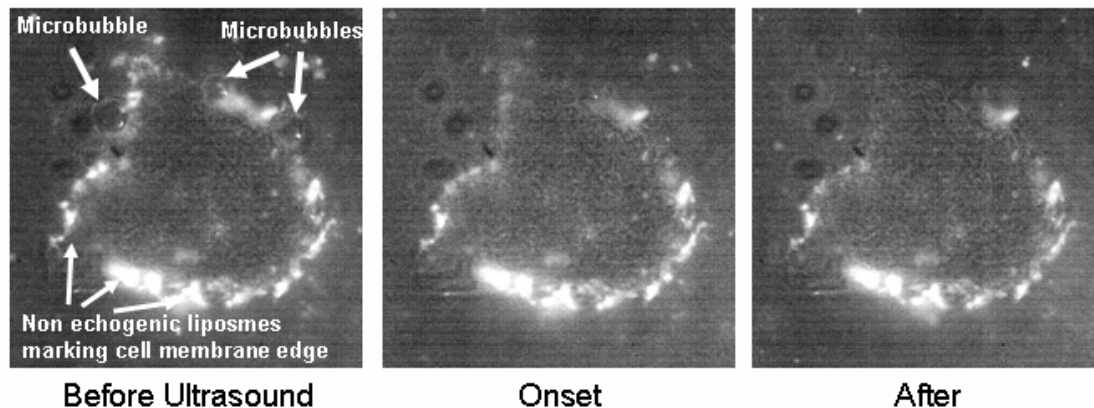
Fluorescent image sequence of the interaction between an echogenic drug delivery vehicle and an artificial cell membrane. The ultrasound pulse sequence was designed to induce a low level rupture and unfolding of the vehicle’s outer membrane.
